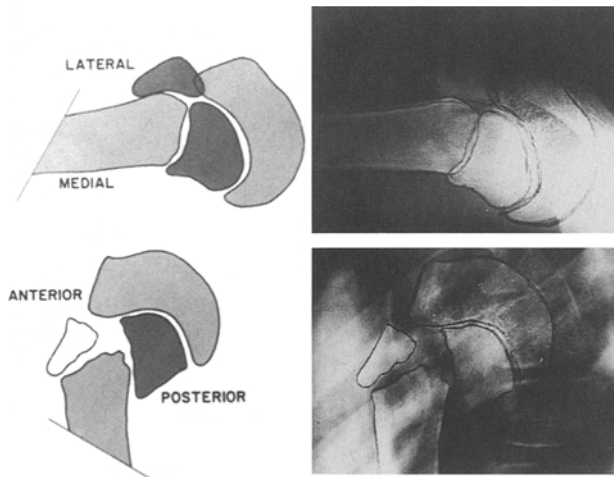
Radiograph with an additional and separate anterolateral metaphyseal fragment
